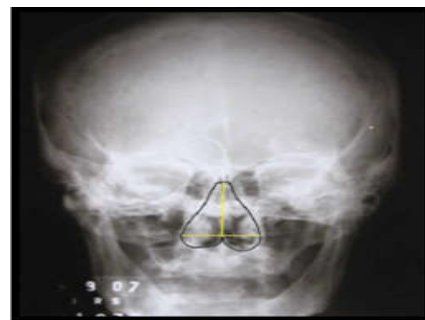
Morphometry of piriform aperture on PA cephalometric radiograph according to Hwang et al.¹³
